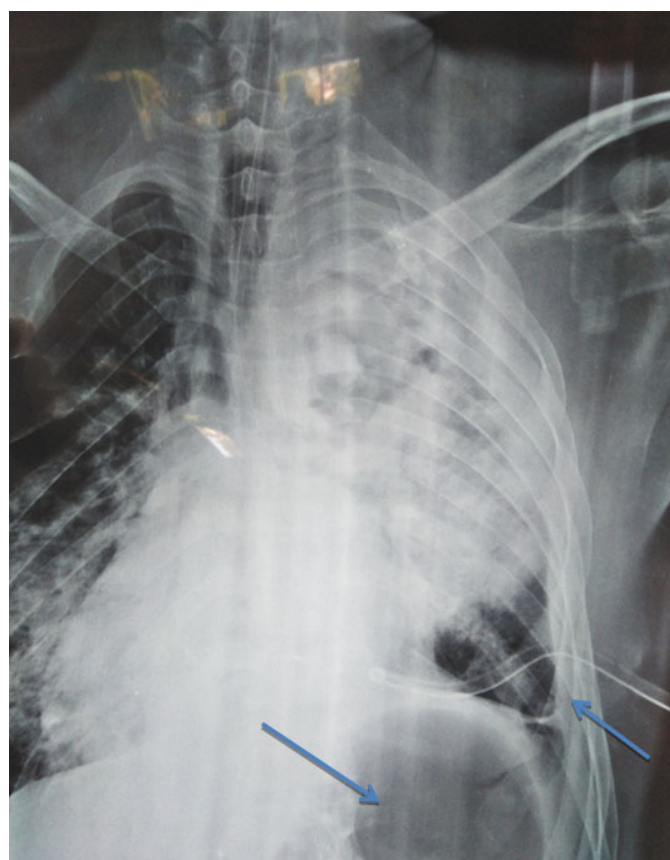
Chest X-ray showing a drain in place with lung returning to the chest wall and a stomach full of air.
